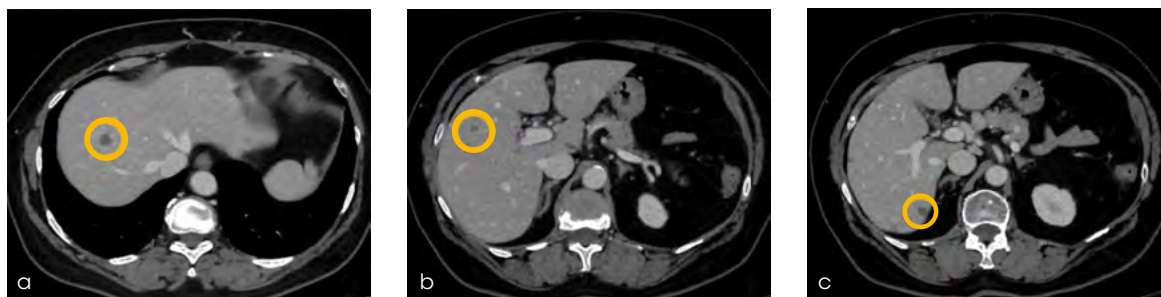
3-month post-treatment CT scans show almost complete tumor necrosis (a-c)
